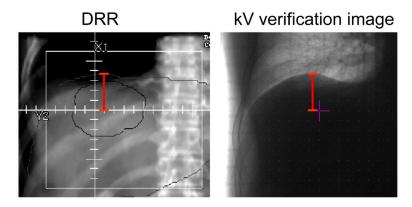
Use of an AP kV image to assess superior-inferior positioning of a patient treated using breath hold for liver immobilization. Left=DRR from planning CT (exhale helical under ABC), Right: kV image at breath hold
